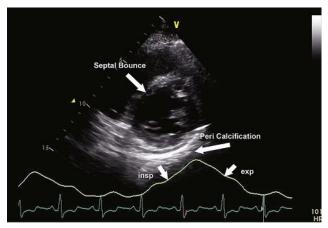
CP: 2D parasternal short-axis view in a patient with CP. *Arrows* point to the onset of inspiration and onset of expiration; pericardial calcification and the interventricular septum where flattening of the septum is apparent in diastole consistent with a septal bounce (Video A9). These are the features that are consistent with CP.
